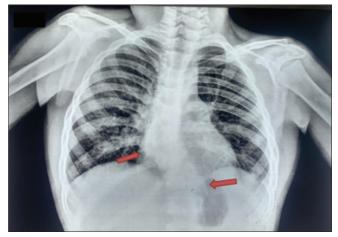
Chest X-ray shows S-shaped curvature in vertebral column in thoracic region with hemivertebrae (shown by an arrow) and the underdeveloped acromion process of the scapula on the left side
